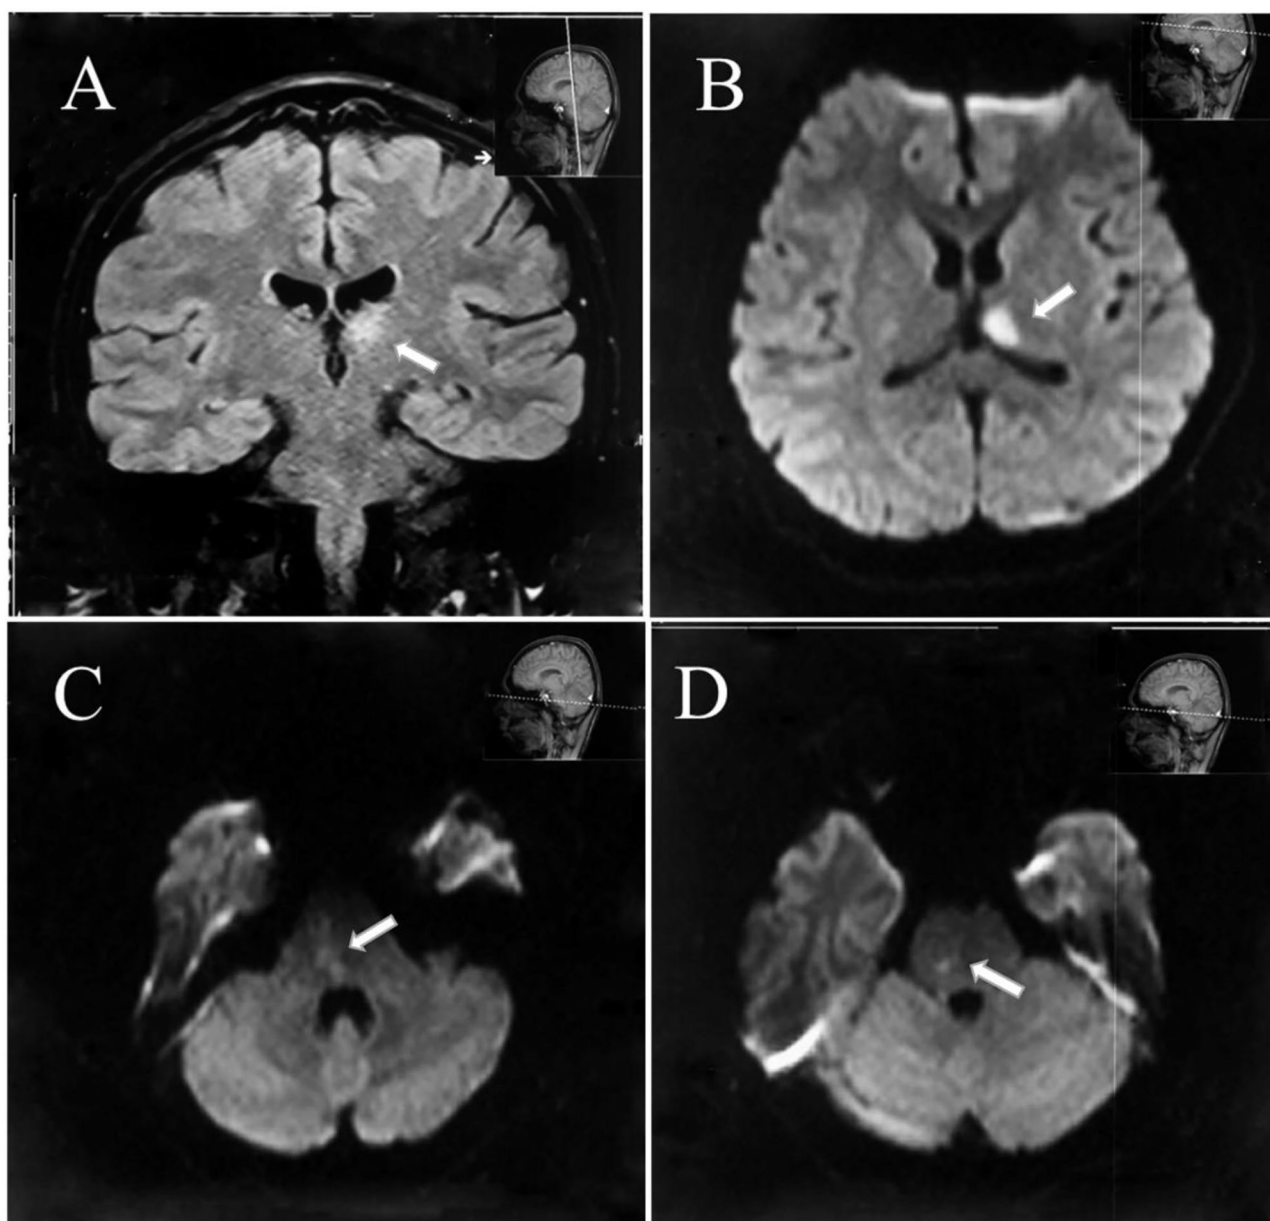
Diffusion restriction of the left thalamus (A,B) and the right brain stem as demonstrated on diffusion-weighted magnetic resonance imaging consistent with acute ischemic infarction (C,D).
